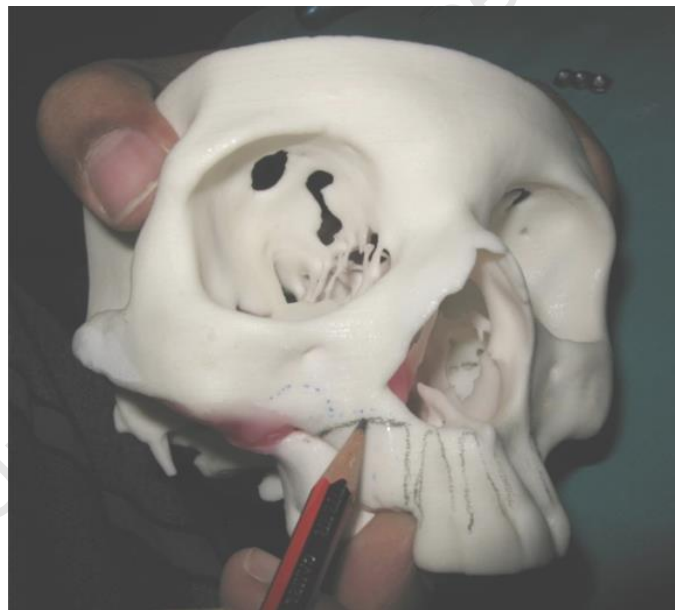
Pre-operative planning of surgery facilitated by CT imaging and rapid-prototyped cranial models.
